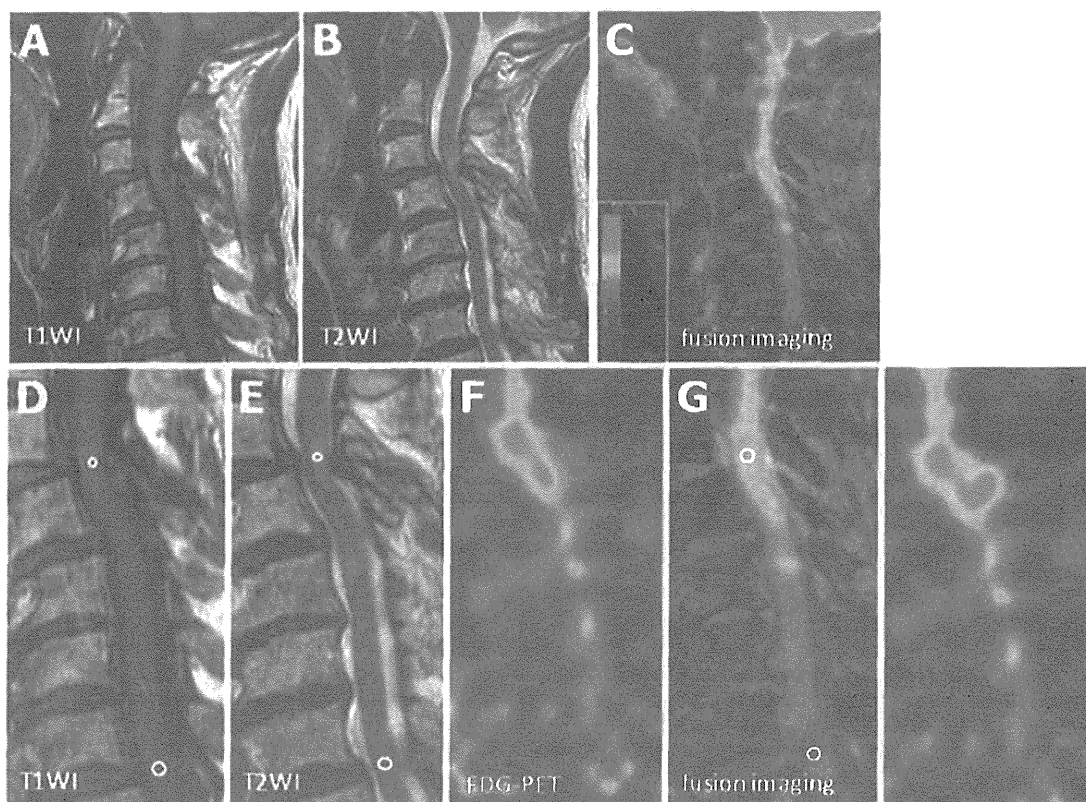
An 80-year-old woman with cervical spondylotic myelopathy was treated surgically and showed a neurological improvement rate of 75.0 % at follow-up. (a) Midsagittal T1-weighted MRI, (b) midsagittal T2-weighted MRI, (c) MRI/PET fusion imaging (d, e), (f) ^{18}F -FDG PET sagittal image, and (g) MRI/PET fusion sagittal slice demonstrate a focal increase in ^{18}F -FDG uptake at the level of increased signal intensity lesion (Reprinted, with permission, from [29])
